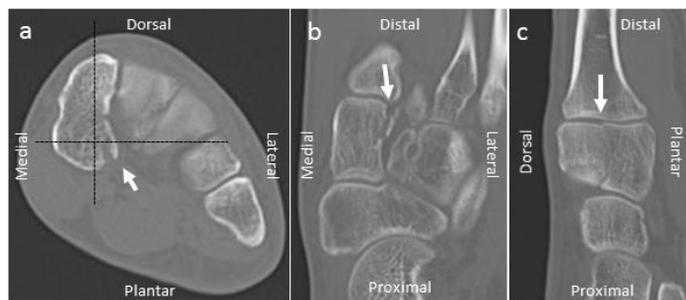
Computed tomography of the foot in the first patient. White arrows show fracture line. Dotted lines in axial image (a) show reference lines for coronal image (b) and sagittal image (c).
